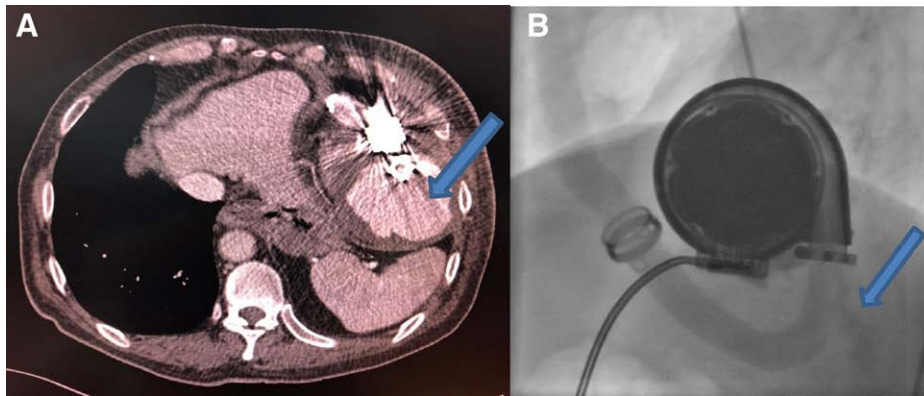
A: Computed tomography with contrast. B: Left ventriculography in angulation cranial 64, Right anterior oblique – 19; volume 28 ml, rate 14 ml/sec, Pounds per square inch – 750)
